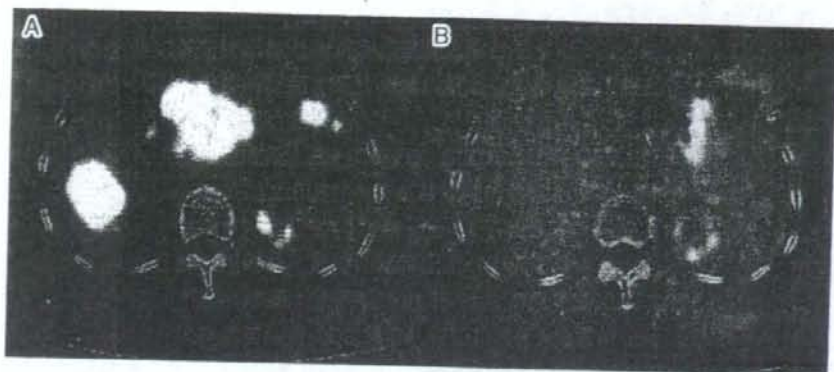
FDG-PET/CT. Patient 1. A. Before chemotherapy. Abnormal uptake was seen in multiple metastatic lesions in both liver lobes. B. After chemotherapy. No abnormal uptake was observed.
